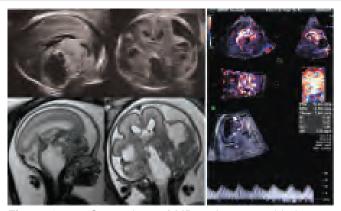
Comparison of MR and sonographic images in a case of brain tumor at 26 weeks of gestation (upper left and middle) Sonographic median and anterior-coronal images. (lower left and middle) MR median and anteriorcoronal images. Note the huge tumor below the oppressed bilateral hemispheres and oppressed brainstem. (upper right) Three orthogonal view and reconstructed image by 3D bidirectional power Doppler. (lower right) Intratumoral blood flow with low resistance is demonstrated. Intracranial morphology is more comprehensive by MRI than sonography due to MR feature of more contrast between different tissues, however, sonography is much more helpful in assessment of intratumoral vasculature and blood flow analysis
